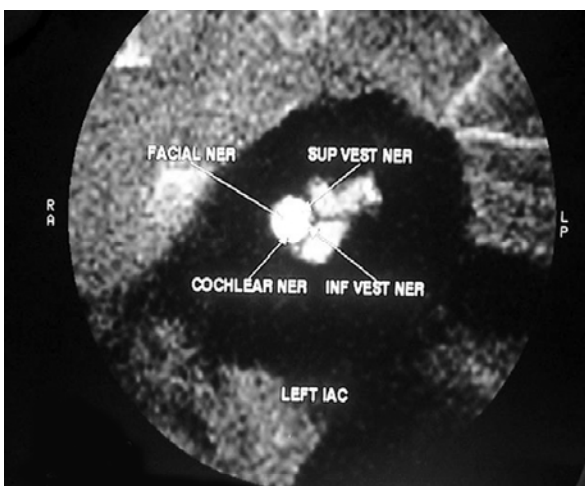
MRI of the internal auditory meatus showing intact cochlear nerve
